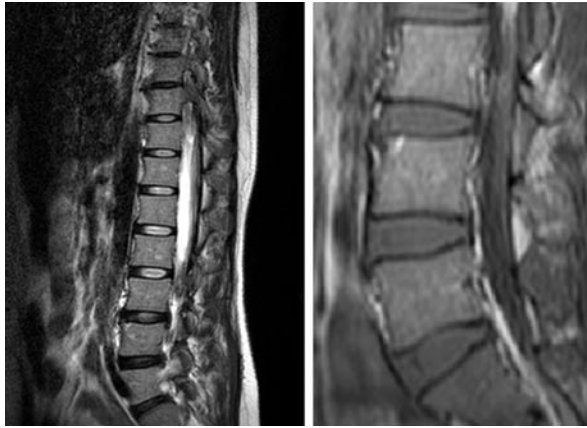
Magnetic resonance imaging does not reveal any abnormality. Posterior arch elements are normal.
